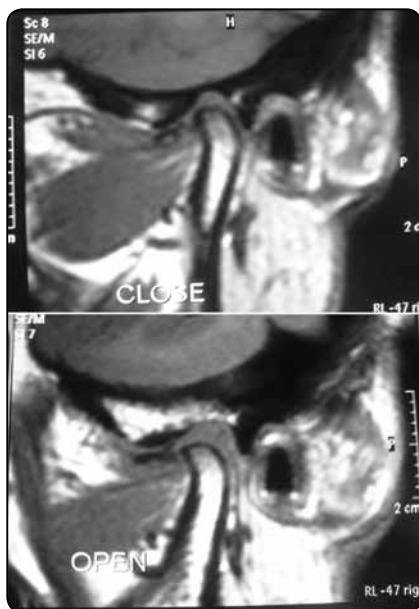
Preoperative MRI showing closed lock
